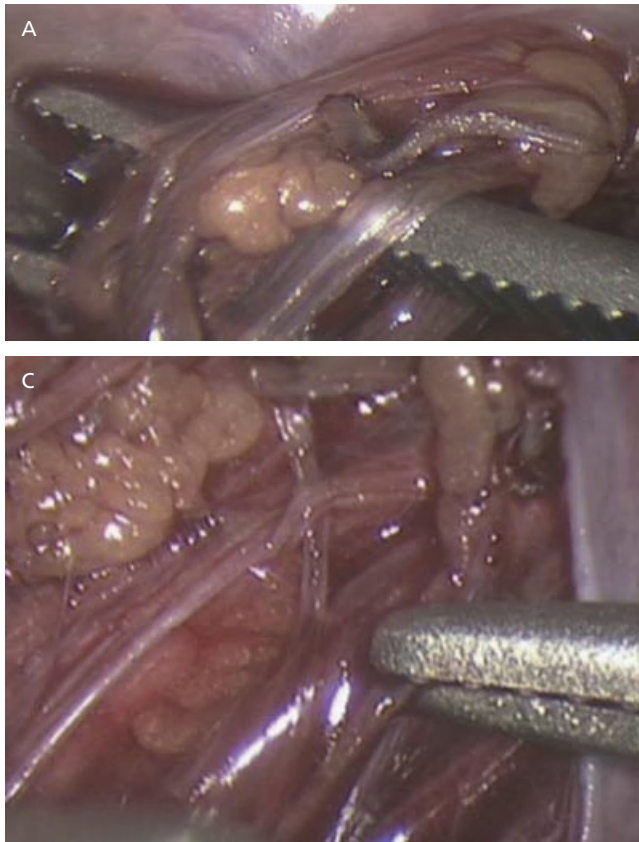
Doppler probe used for dissection and identification of the spermatic artery.
